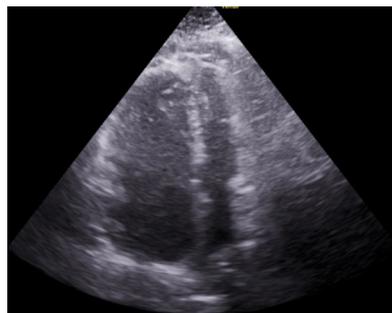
Apical four-chamber view on transthoracic echocardiography.
